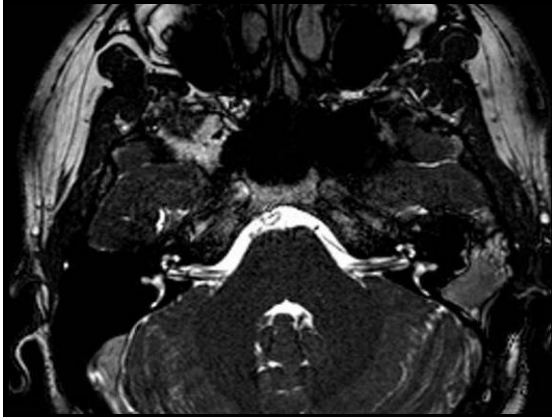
Case 1 diffuse granulation at middle ear on temporal MRI.
